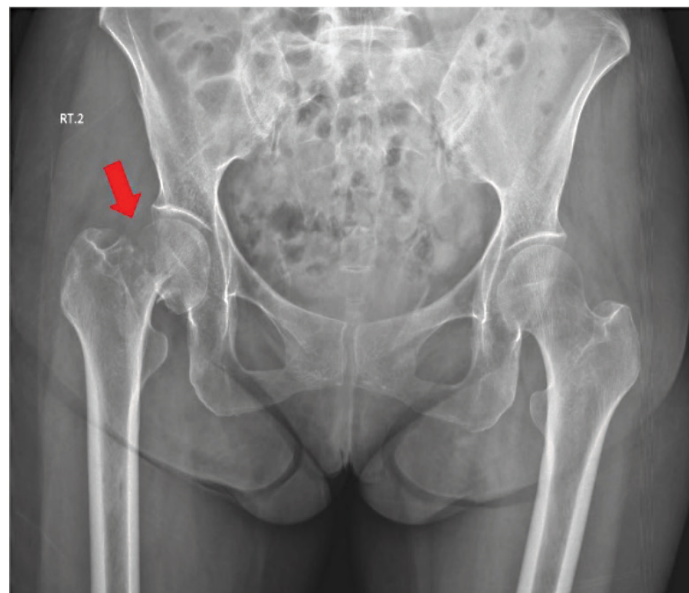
Plain radiograph shows displaced right femoral neck fracture.
